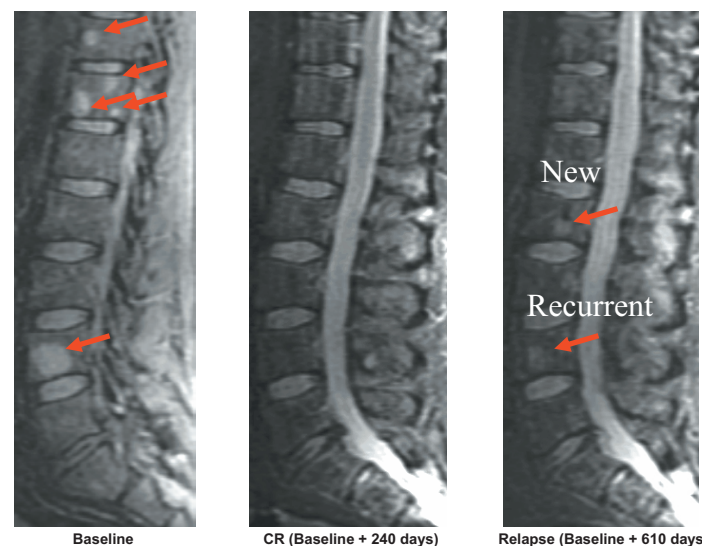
A series of sagittal Short-tau Inversion Recovery-weighted (STIR-wt) images of the lumbar spine from a patient with multiple myeloma is shown. The baseline examination (left) demonstrates MRI-FL (arrows) which resolve at CR (center). At relapse (right), the lower MRI-FL is seen to be recurrent while the upper MRI-FL is seen to be new. Additionally, the number of MRI-FL at relapse is fewer than the number seen on baseline examination.
